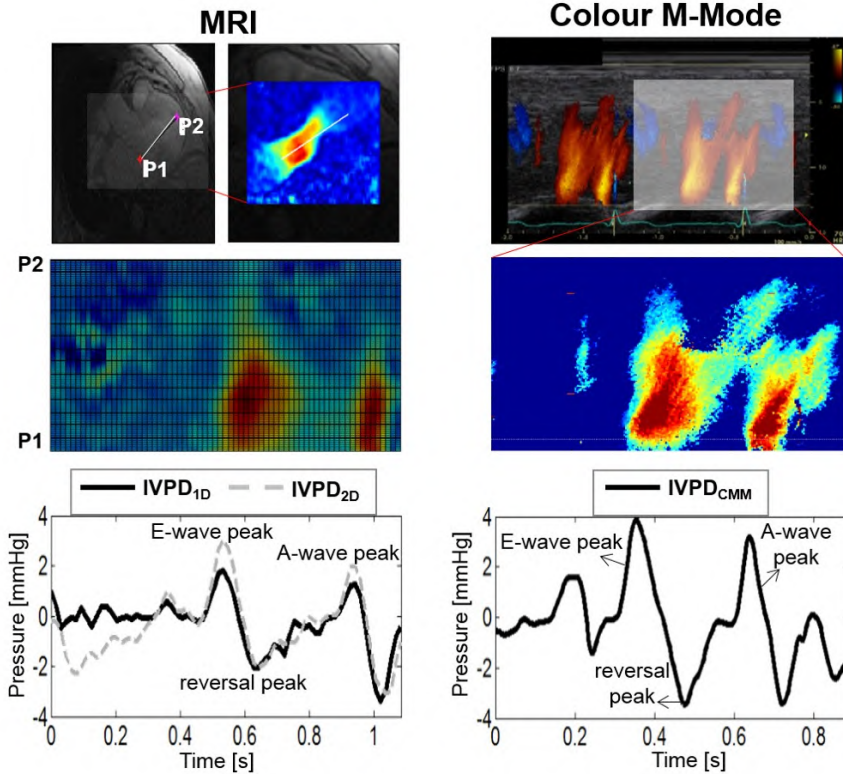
Cardiac MRI (left) and CMM (right) based methods to estimate IVPDs. Top) a ROI selection by the user inside an original recording example (from the same patient). Middle) processing results used to calculate and extract all parameters. Bottom) IVPD derived from the application of imaging velocity data to solve equation (4.2); left) solid black line: $IVPD_{1D}$; gray dashed line: $IVPD_{2D}$, right) solid black line: $IVPD_{CMM}$. Figure adapted from [2].
